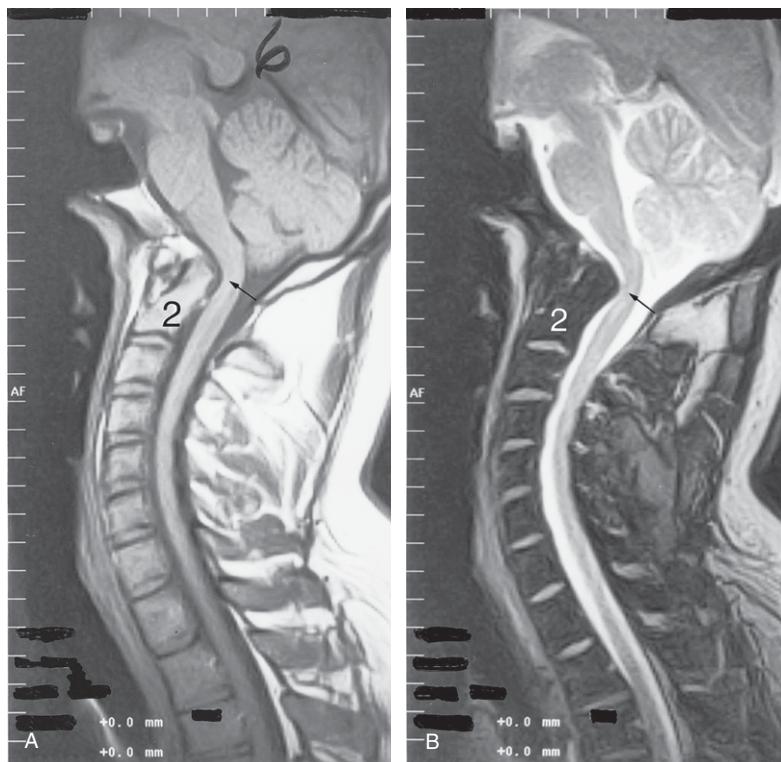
(A) Cervical spine MRI sagittal T2-weighted image. The second cervical vertebra (2) is shown with its odontoid peg impressing upon the anterior aspect of the brain stem/cord that is sharply angulated (small black arrow). (B) Cervical spine MRI sagittal T1-weighted image. The second cervical vertebra (2) is shown with its odontoid peg impressing upon the anterior aspect of the brain stem/cord that is sharply angulated (small black arrow).
